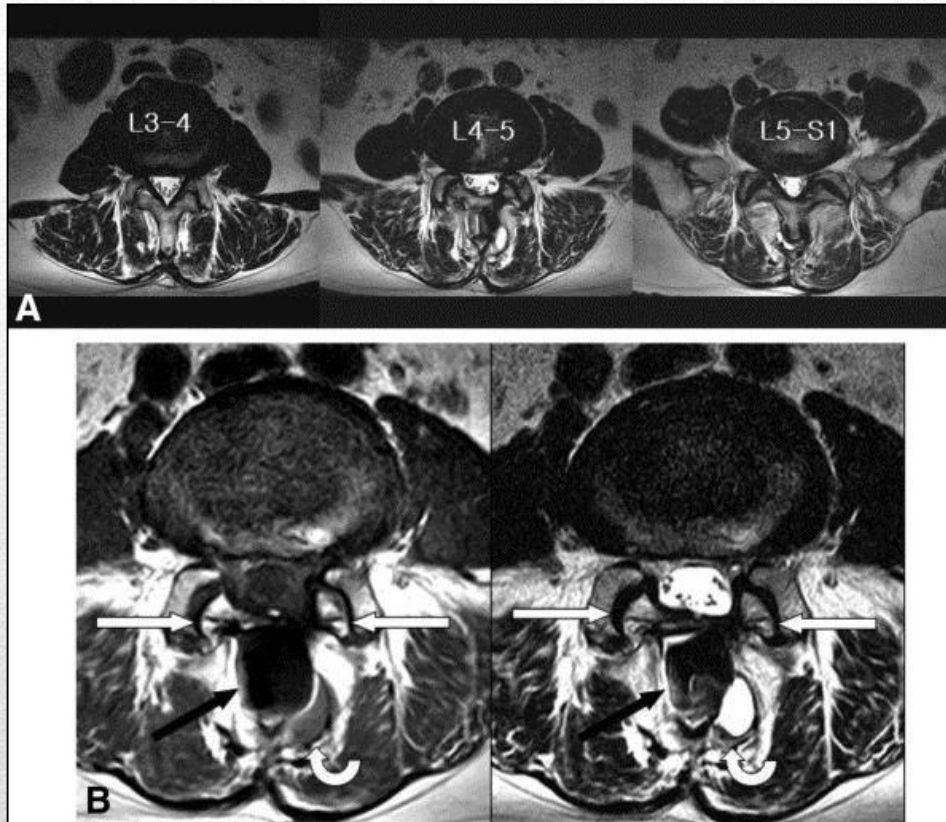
A, Spinal stenosis was found from L3 to S1 on sagittal and axial images. B, Linear low signal suggesting fractures of bilateral inferior articular processes of L4 are seen on axial scans of T1-weighted image and T2-weighted image (white arrows). There is interspinous device showing metallic artifact (black arrow) and adjacent fluid collection (white curved arrow).
